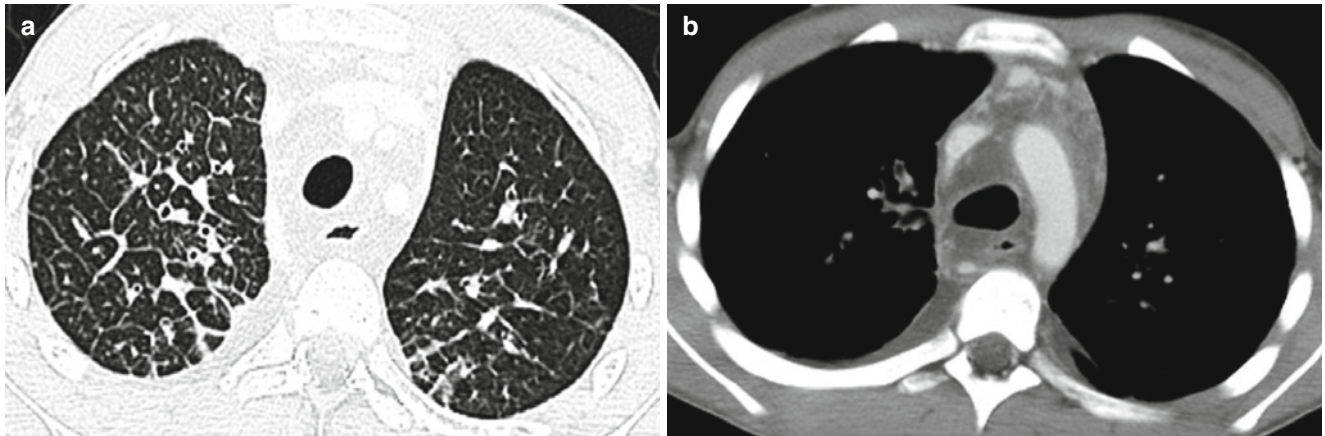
Pulmonary lymphangiomatosis in a 5-year-old boy. (a) Axial lung window CT image shows interlobular septal thickening in both lungs. (b) Axial soft tissue window CT image demonstrates mediastinal edema and bilateral pleural effusions
